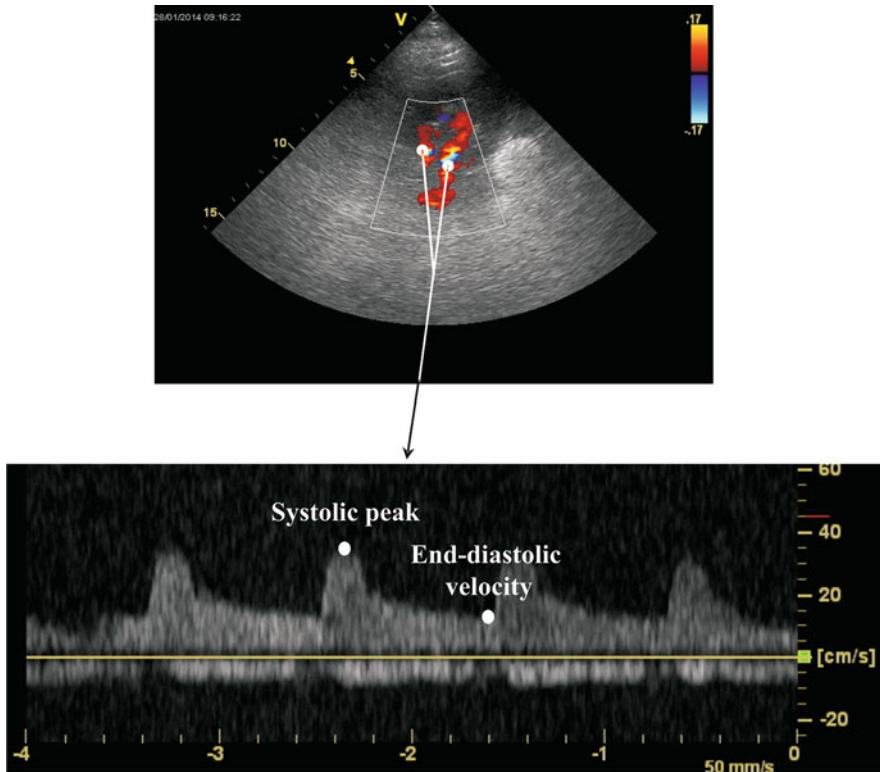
Renal resistance index calculation. Calculation of the renal resistance index. The renal arterial Doppler was performed using a 4 MHz probe with the patient in the sitting position and using a posterior approach to visualize the kidney. The course of the segmental arteries is visualized by color Doppler flow, and, at the middle tract level of the best one visualized, pulsed wave Doppler is performed. Peak systolic velocity and end-diastolic velocity are used to calculate the renal arterial resistance index according to Pourcelot formula
